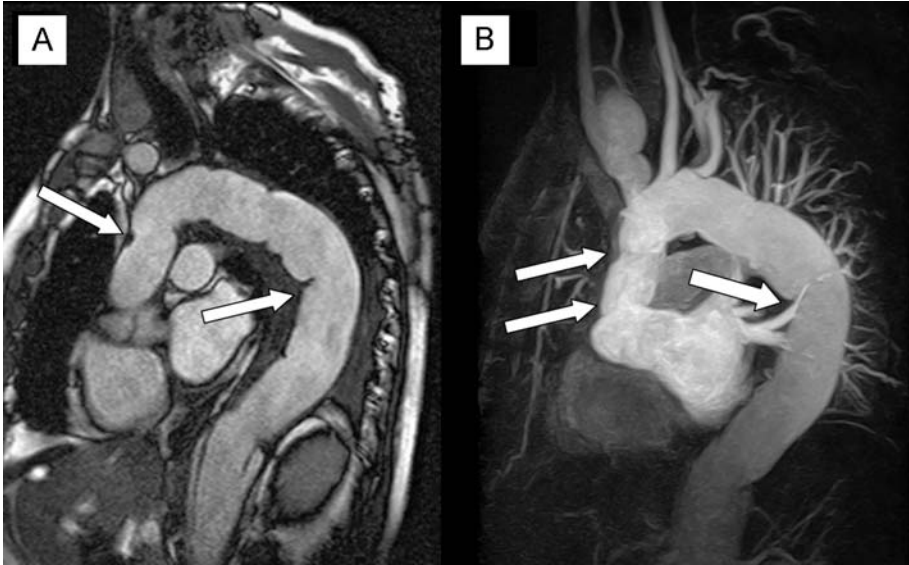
MRI images of a patient with multiple aortic operations. The patient had a type A aortic dissection. A hemiarch was implanted. A few years the descending aorta dilated and was replaced. The right subclavian artery is dilated. A: SSFP sequence, sagittal oblique plane shows the anastomoses in the ascending and in the descending aorta (white arrows). B: Surface reconstruction of a contrast-enhanced 3D angiography. Anastomoses in the ascending and in the descending aorta (white arrows).
